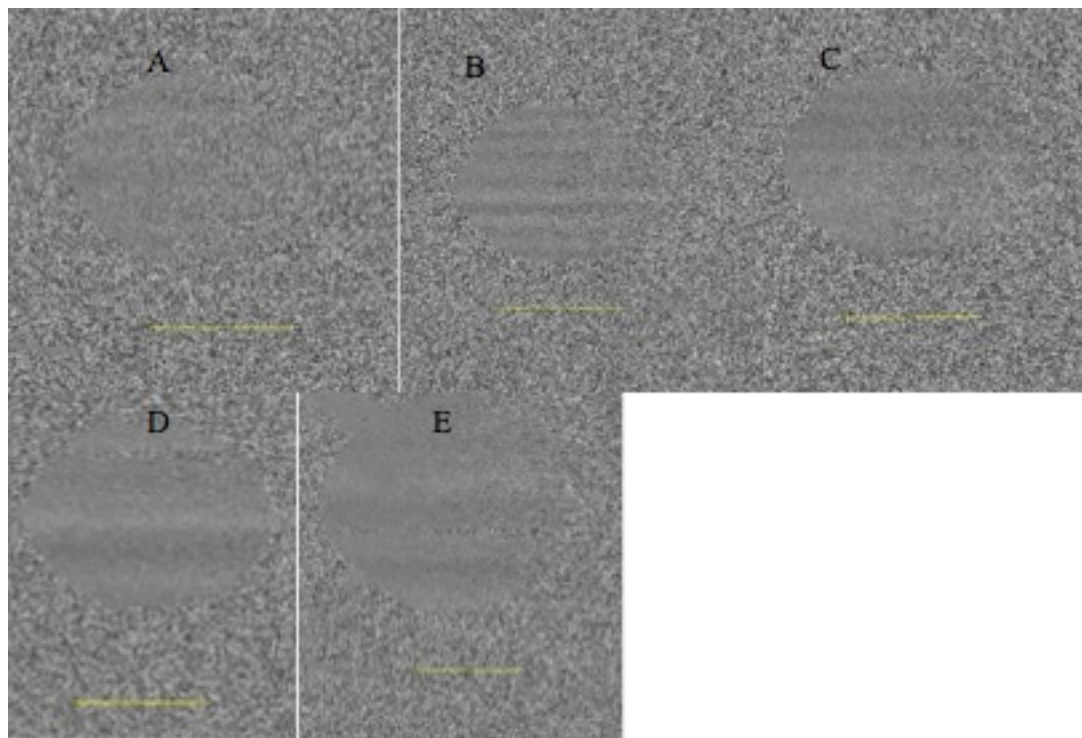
Doppler scans of non-flowing nanorods at a) 0.3, b) 0.4, c) 0.5, d) 0.7 and e) 1×10^{12} GNRs/mL
